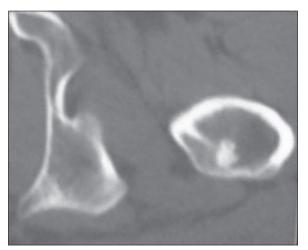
High resolution CT scan showing double nidus in intertrochanteric region
